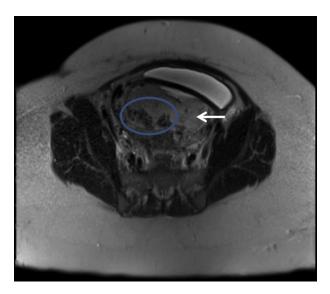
T2-weighted axial MRI. This image depicts dark T2 bands (circled) posteriorly in the placenta (arrow).
